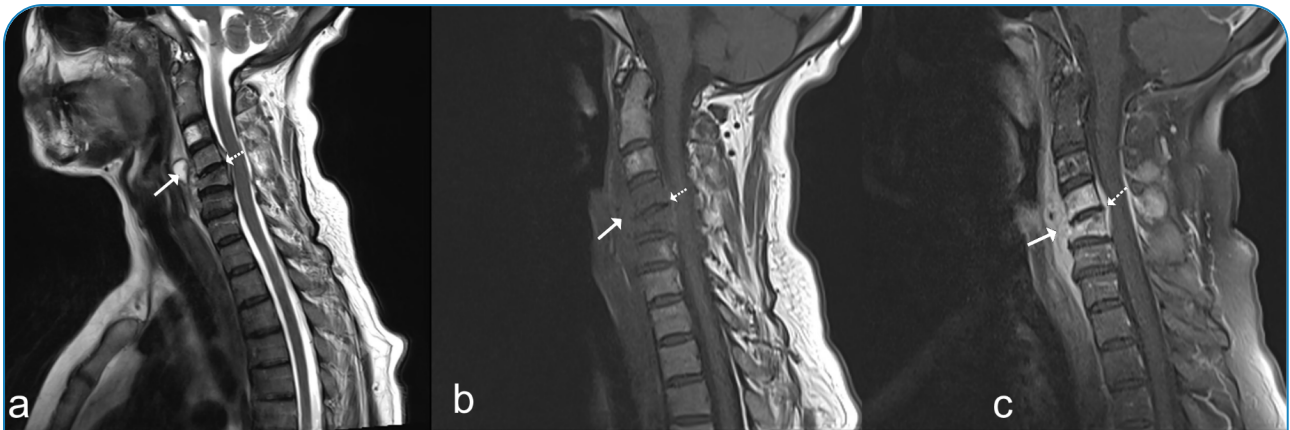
Pre-treatment cervical magnetic resonance images. (a) Non-contrast T1 AG without fat suppression. T1 AG images (b) Fat-suppressed contrast-enhanced; prevertebral abscess (arrow). (c) epidural abscess (dashed arrow).
